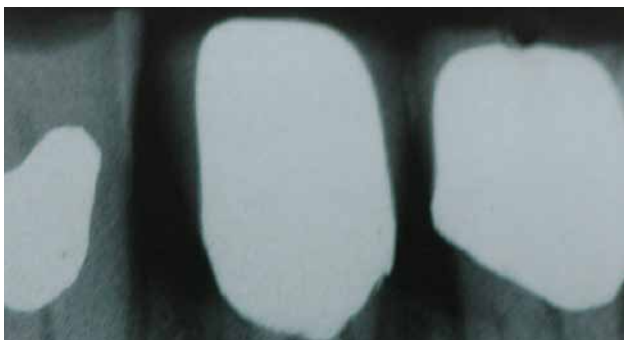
would look like this just a few months later in the X-ray image
